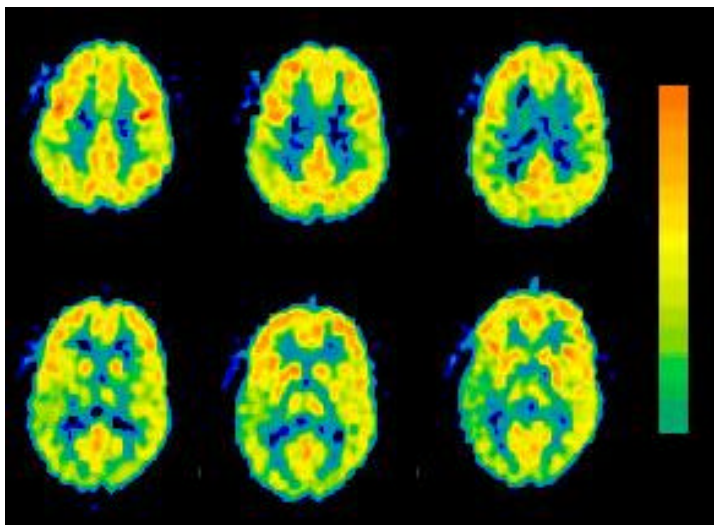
Raw SPECT images have this appearance prior to normalization. The scale on the right indicates magnitude of perfusion; red areas are highly perfused, whereas blue areas receive minimal blood flow.
